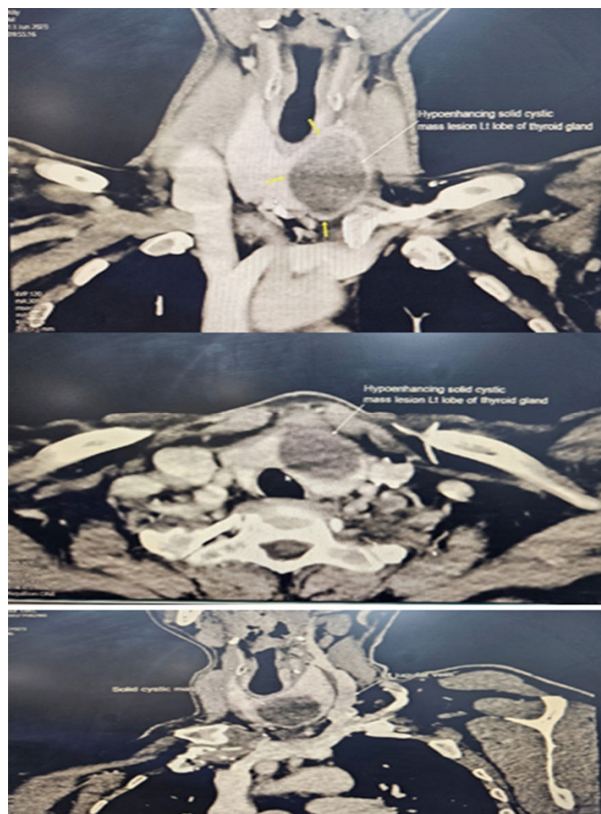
640 Slice CT neck contrast
